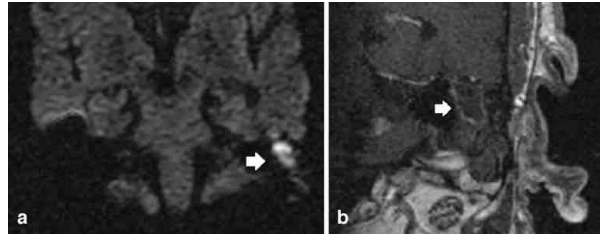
The arrow represents primary acquired cholesteatoma [22], where (a) echo-planar DWI, (b) T1-weight.
